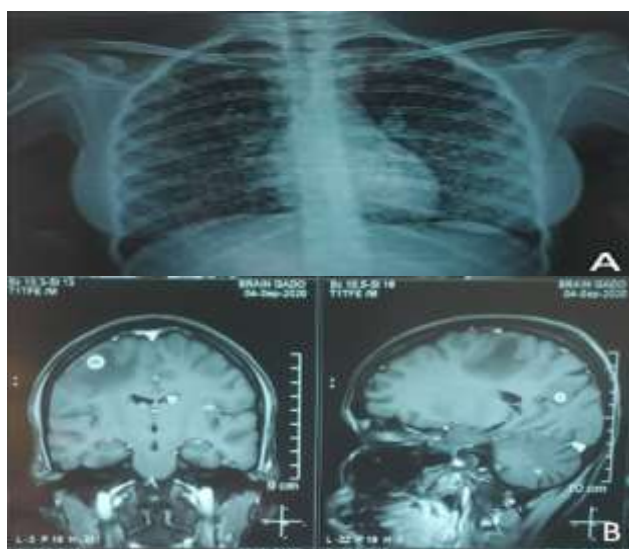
(A and B): Chest X-ray of patient before treatment showing miliary mottling. MRI brain showing well defined ring enhancing lesions.
